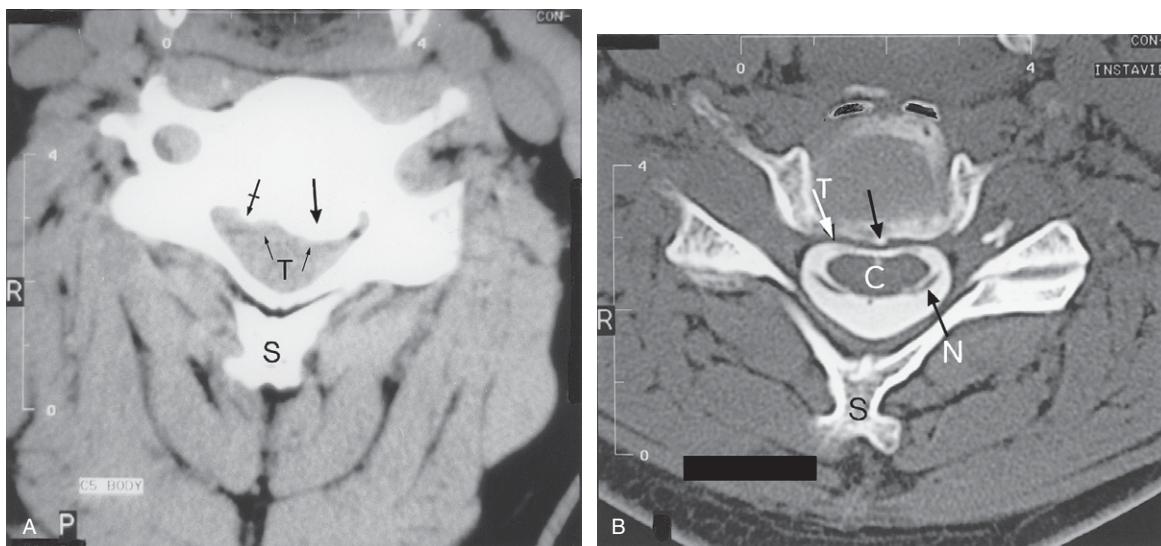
(A) Cervical spine CT axial image showing the C4–5 disc diffuse annular bulge and large left posterolateral osteophyte formation (large black arrow) indenting the thecal sac (T) anteriorly (small black arrows) with moderate spinal canal stenosis and left intervertebral foramen stenosis. There is some bony narrowing of the right C4–5 neural foramen due to degenerative changes in the adjacent uncovertebral joint (tailed arrow). R = right side of patient; S = spinous process. (B) Cervical spine CT myelogram from another patient showing how even a small posterior osteophyte (black arrow) will indent the anterior pain-sensitive part of the thecal sac (T) which contains the spinal cord (C) and nerve roots (N). Therefore, a large posterolateral osteophyte with diffuse annular bulging of the disc, causing left canal stenosis, would affect the tracts within the spinal cord with symptoms in the legs due to cervical cord myelopathy. R = right side of patient; S = spinous process.
